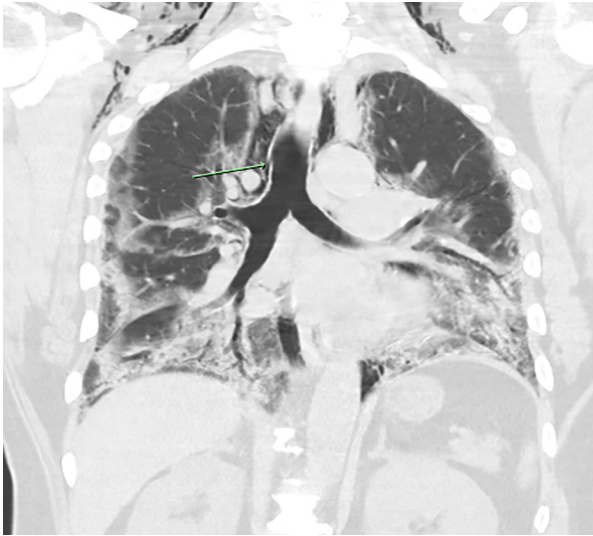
Coronal CT image with an arrow highlighting tracheal breach. Peripheral consolidative and ground-glass opacities in lung fields most prominent in the bilateral lower lobes.
